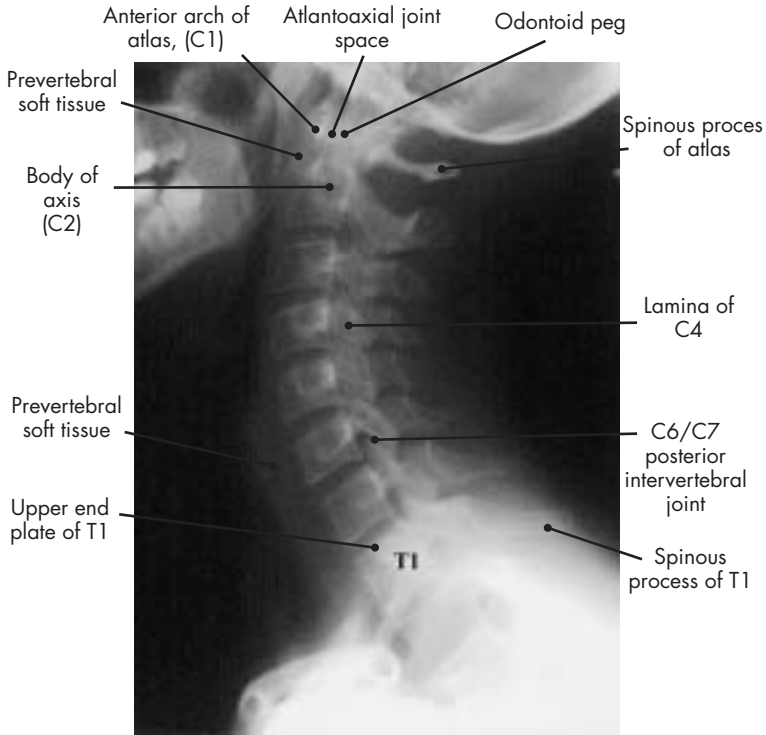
X-ray heaven! Excellent lateral view of neck showing vertebrae down to T1 and beyond.
